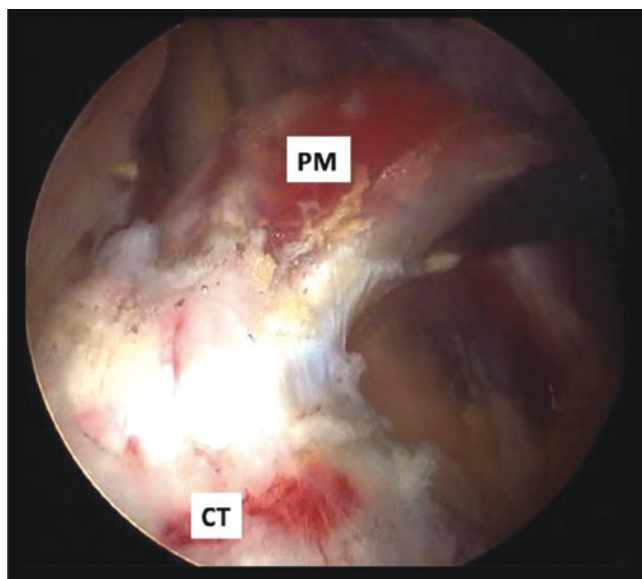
Visualization from portal I. We observe the coracoid process, conjoint tendon (CT), and pectoralis minor (PM) free of adhesions prior to being disinserted
